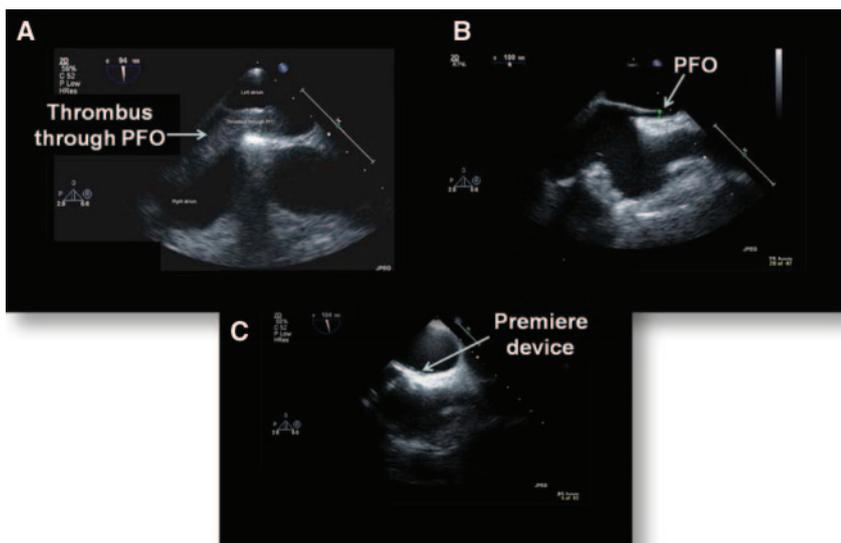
a, Transesophageal echocardiogram demonstrated a massive intracardiac thrombus extending through a PFO into the left atrium. b, Transesophageal echocardiogram after anticoagulation revealed PFO with no residual thrombus. c, Transesophageal echocardiogram confirmed closure of PFO with a percutaneous endovascular device (Premiere device) (See Data Supplement Movie).
